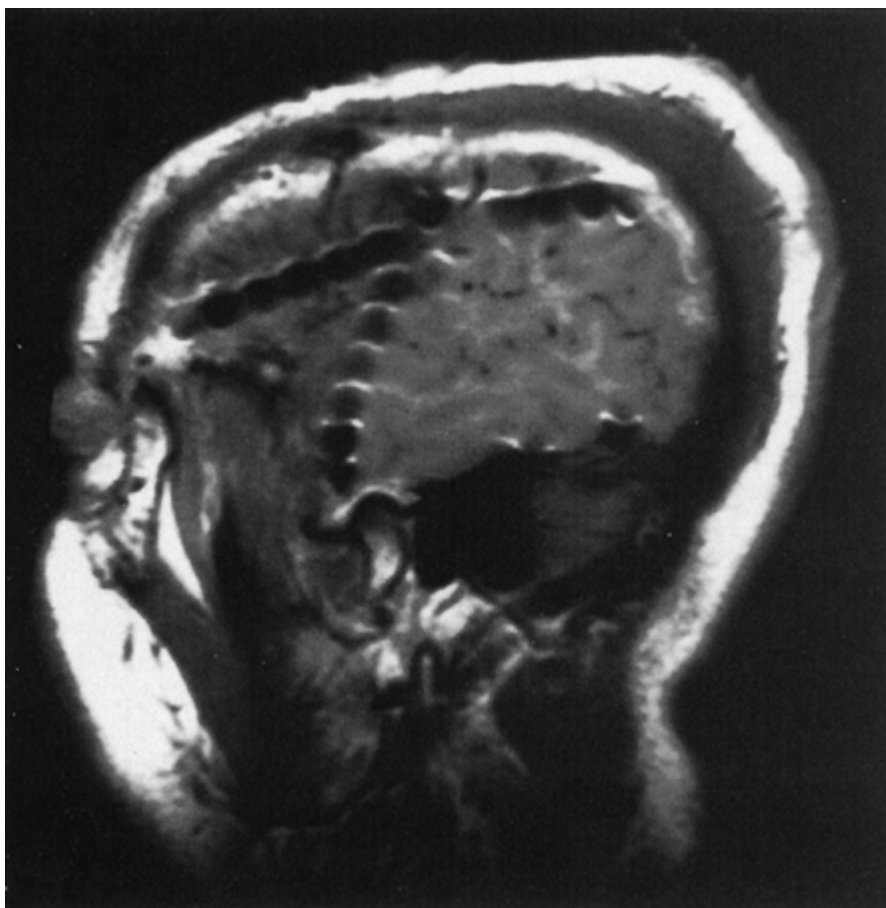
Sagittal magnetic resonance imaging (MRI) view of multiple subdural strips placed through a single burr hole; individual contacts can be identified.
